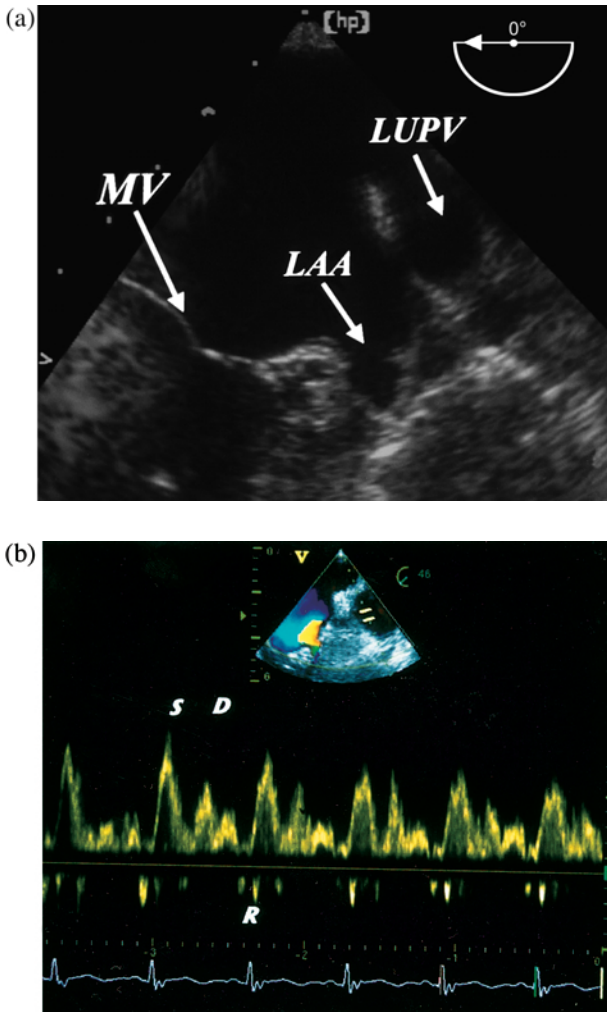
(a) Left atrial appendage and left upper pulmonary vein. (b) Pulsed Doppler recording of normal pulmonary venous inflow in the left upper pulmonary vein.
